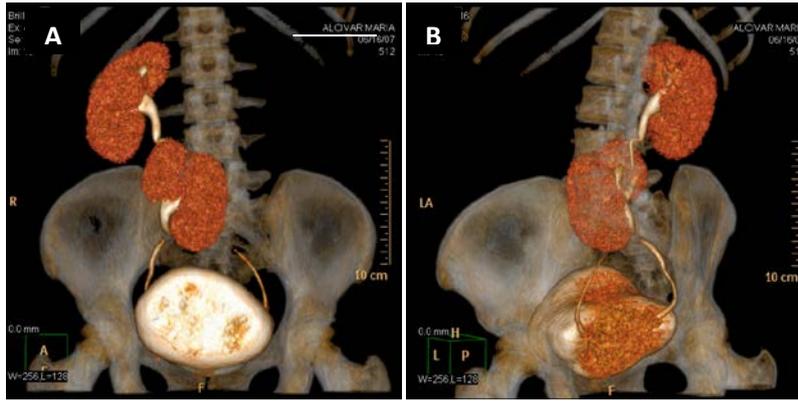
ERC without fusion in a woman of 57 years old. Volumetric reconstruction in CT. (A) Coronal. Empty left flank and left RE contralateral lumbar position, which does not contact the right renal unit. (B) Sagittal oblique. Note ureteral junction thereof with preserved bladder insertion.
